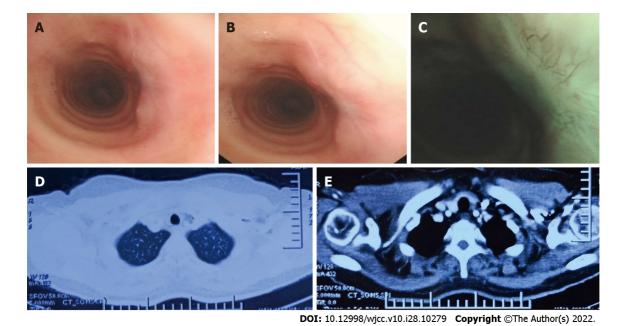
Postoperative re-examination. A-C: Bronchoscopic view; D and E: Computed tomography scan of the chest.
